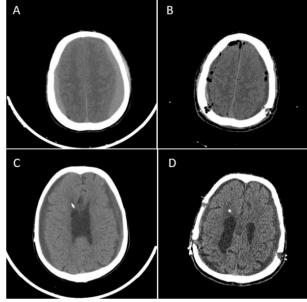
Pre-operative axial CT scan of bilateral chronic subdural hematoma is seen (A). CT scan after bilateral burr-hole drainage (B). Another patient with VP shunt and bilateral chronic subdural hematoma is shown (C). Post-operative image after burr-hole drainage is appreciated (D). (CT. Computed tomography, VP. Ventriculoperitoneal)
